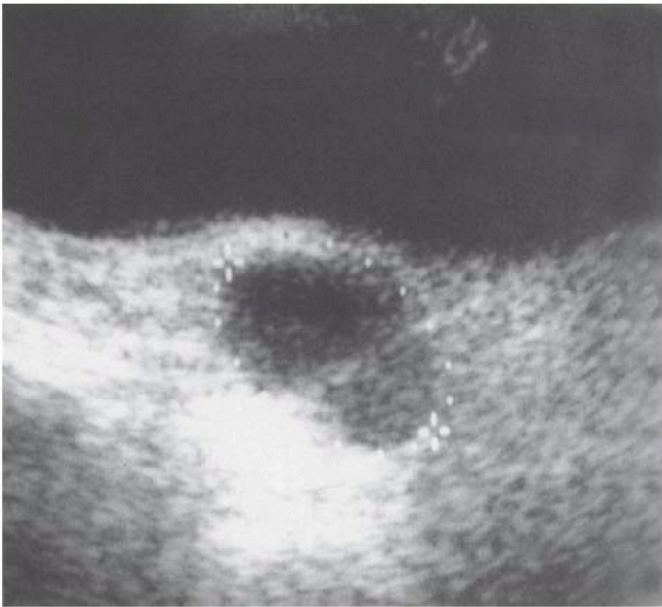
Abdominal sonogram showing a residual ovary with presumed follicular activity.
